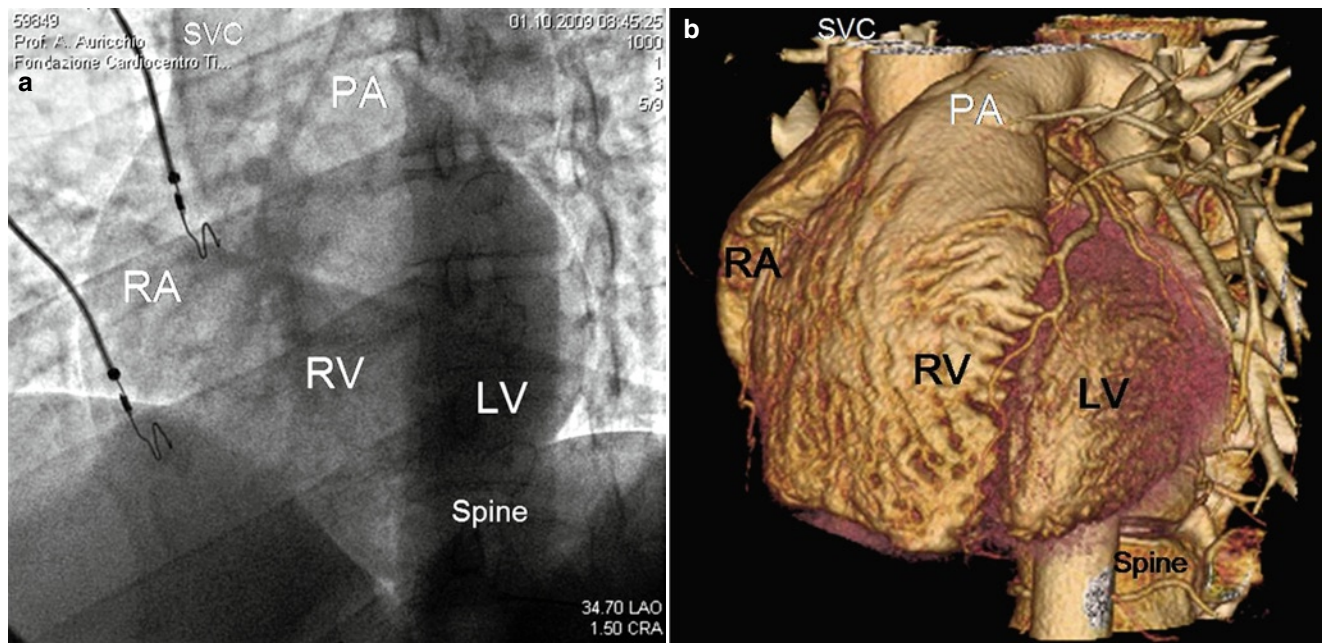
(a) Fluoroscopic image in left anterior oblique projection and (b) the corresponding 3D CT volume rendering. RA Right atrium, RV right ventricle, PA pulmonary artery, SVC superior vena cava
